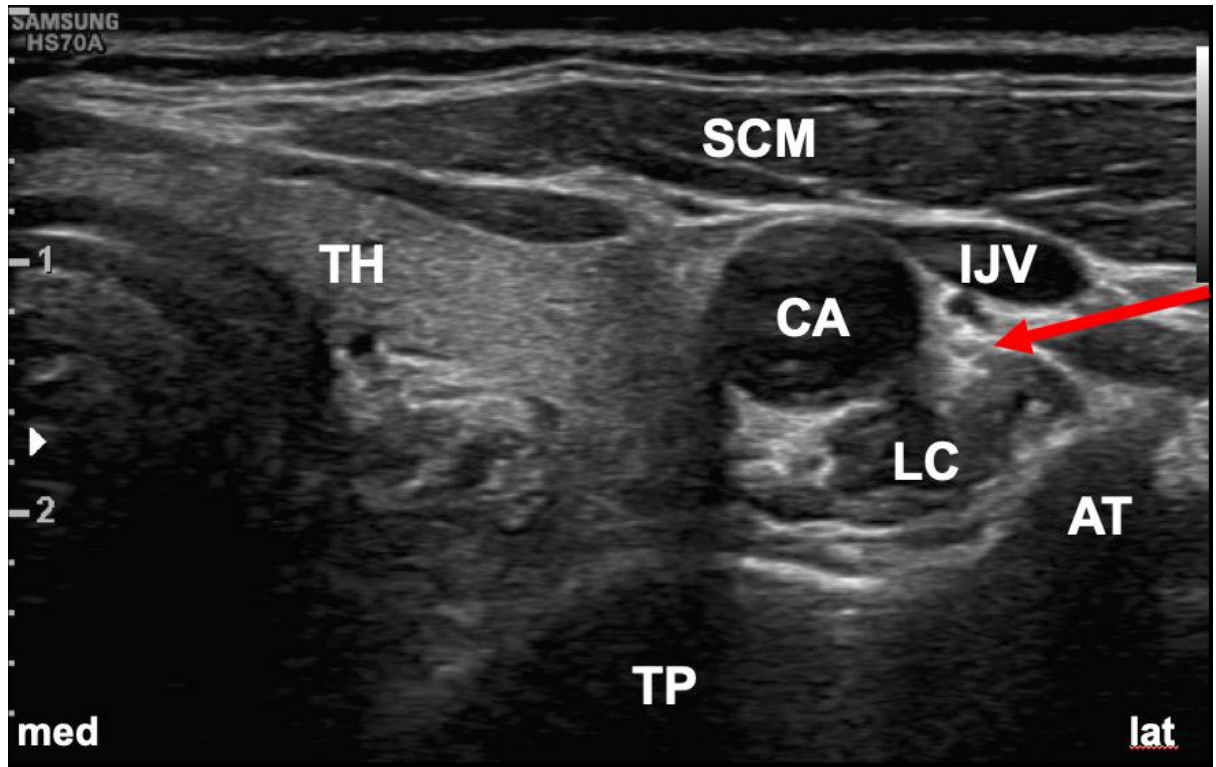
Ultrasonography imaging of Stellate ganglion block at C6 level.
